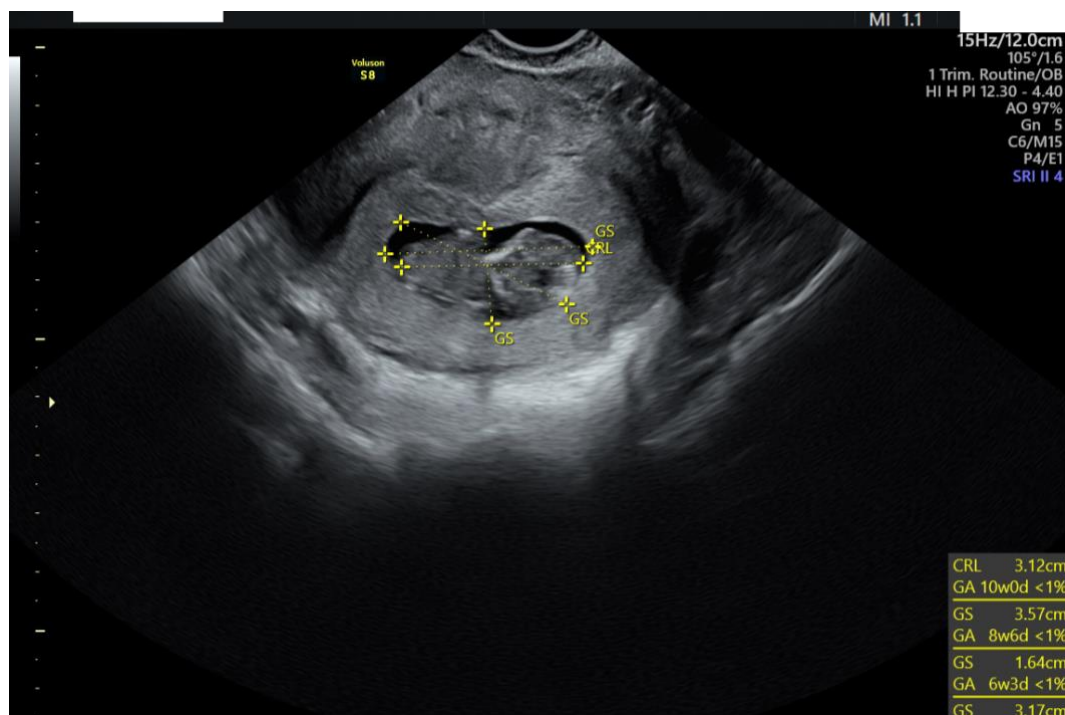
Transvaginal ultrasound showing disproportion between gestational sac size and embryonic length, with reduced GS–CRL difference.
